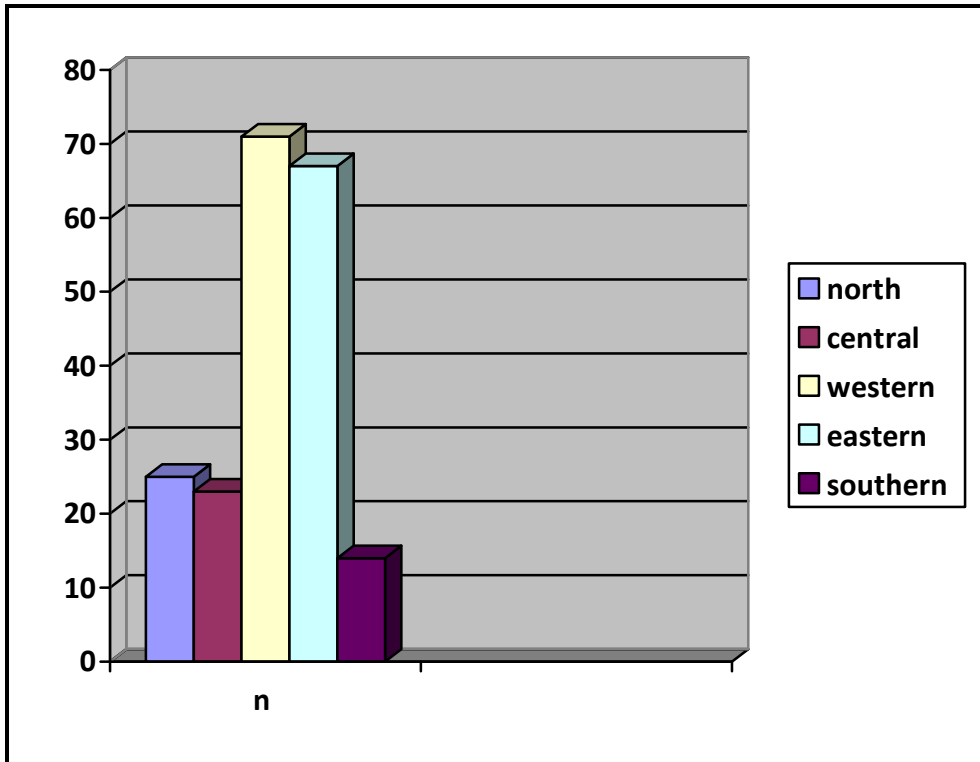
shows the Distribution of the study sample according to tribal origin, among 200 pregnant women presented for obstetrical ultrasound investigation.
